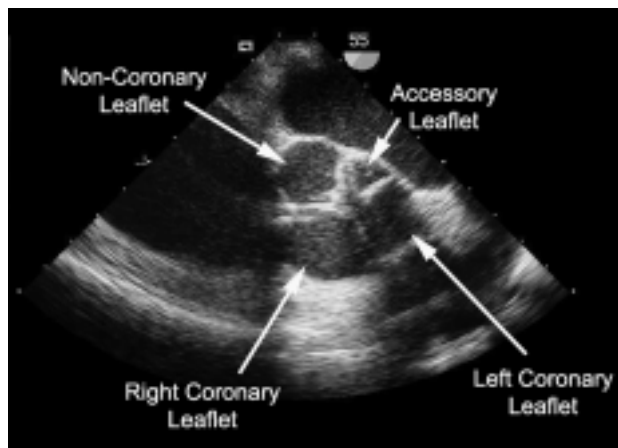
Intraoperative transesophageal echocardiography: a mid-esophageal short-axis view of the aortic valve shows the presence of a small accessory leaflet between the non-coronary and left coronary leaflets.
